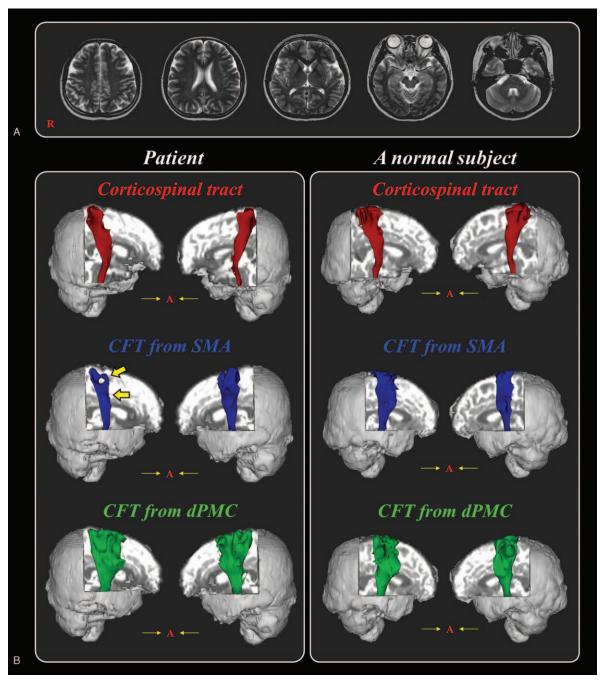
(A) T2-weighted brain MR images at 2 years after onset show no abnormality. (B) On 2-year diffusion tensor tractography, narrowing and partial tearing (arrows) is observed in the right supplementary motor areas-corticofugal tract. MR=magnetic resonance.
